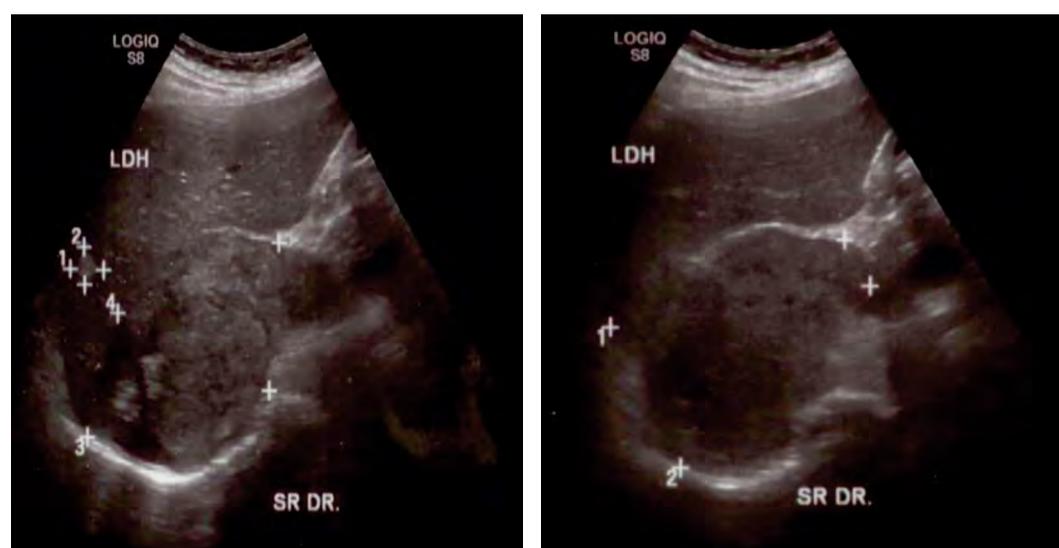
Large right adrenal tumour with liver invasion at abdominal ultrasound (different sections)
